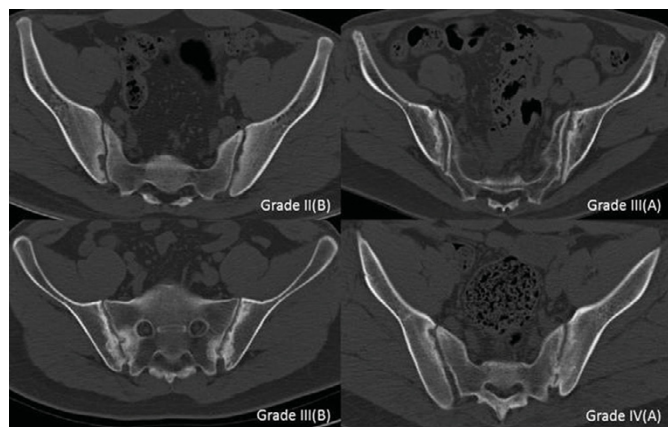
SIJ CT images graded 3 by mNY criteria or Lee criteria, while graded from II(B) to IV(A), respectively, by Innsbruck criteria.
